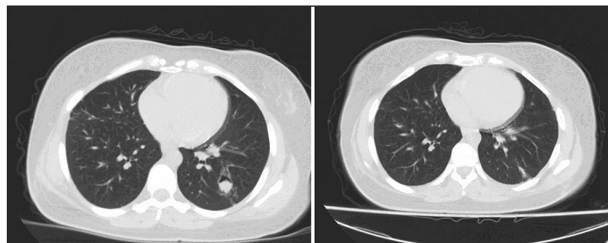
The left panel shows computed tomography (CT) image of the patient before surgery and the right panel shows CT image of the patient postoperative 6th month
